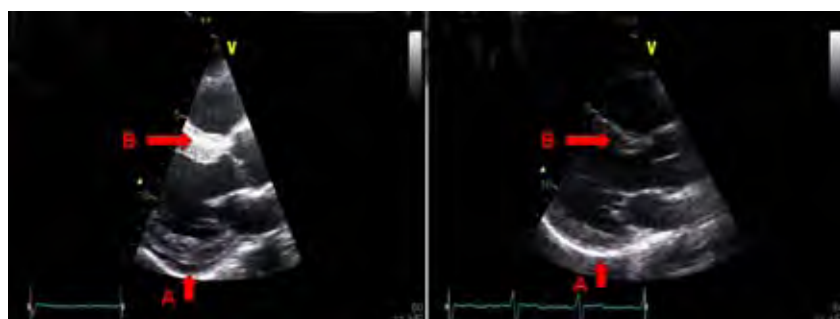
Parasternal long axis views before (left) and after (right) thyroxine replacement. A 1.2 cm pericardial effusion (A) and moderate (1.7 cm) septal hypertrophy (B) were noted before treatment, both of which resolved on follow-up scanning
